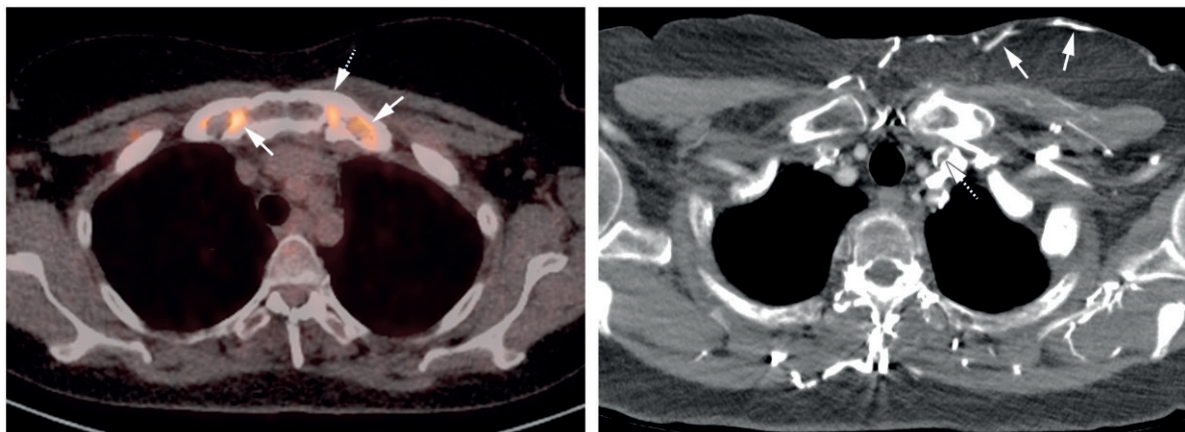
Single-photon emission CT and contrast CT of the anterior chest wall demonstrating CNO/SAPHO complicated by subclavian vein obstruction. Left pane: arrows indicate sclerosis, hyperostosis and increased uptake of the manubrium and upper ribs. Right pane: arrows indicate obstruction of the left subclavian vein with expansive collaterals
